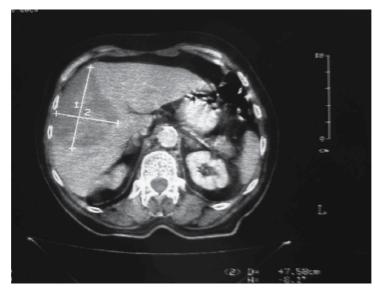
CT image of liver metastasis in Sg4,5,8
